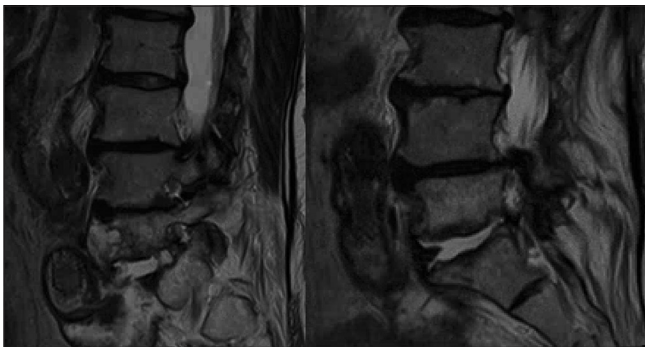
Initial MRI in January 2018 showing L5/S1 osteodiscitis.
